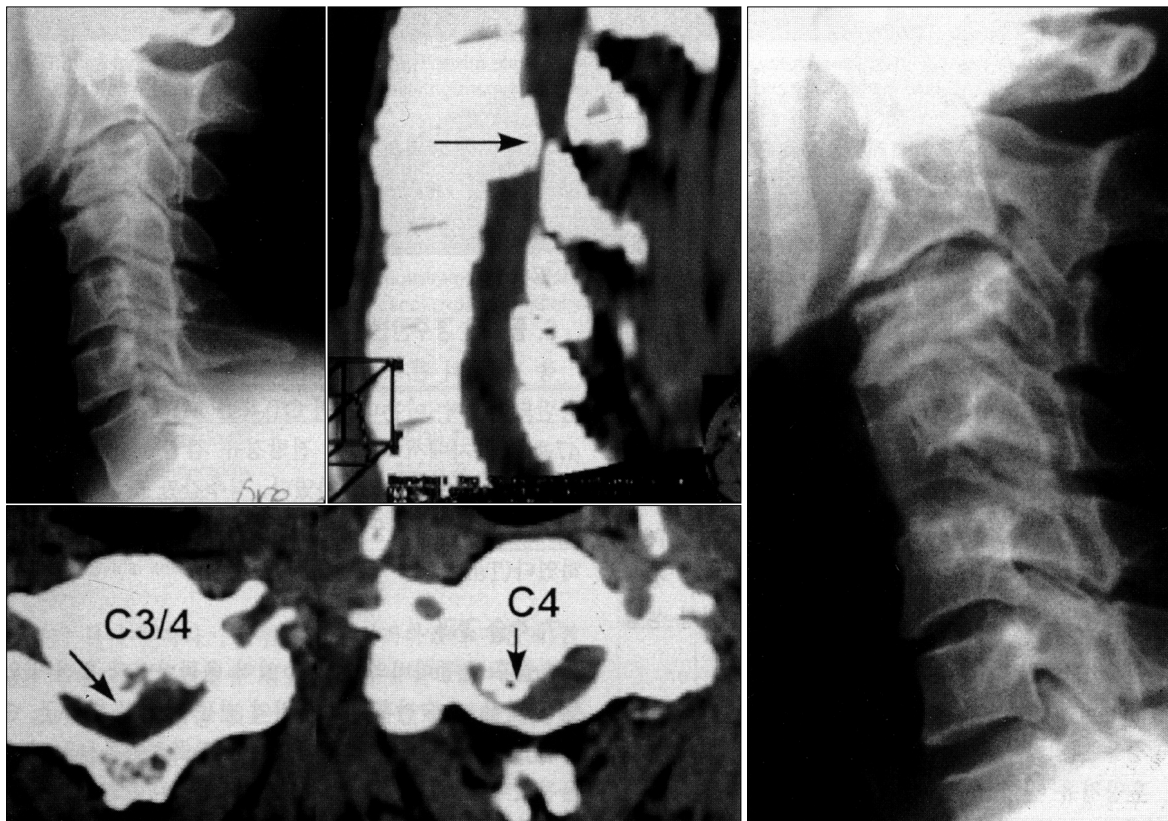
Pre-operative cervical spine lateral X-ray and CT scan demonstrate other type OPLL which compresses spinal cord. Post-operative cervical spine lateral X-ray shows total excision of the OPLL after corpectomy and iliac bone graft with fusion.
